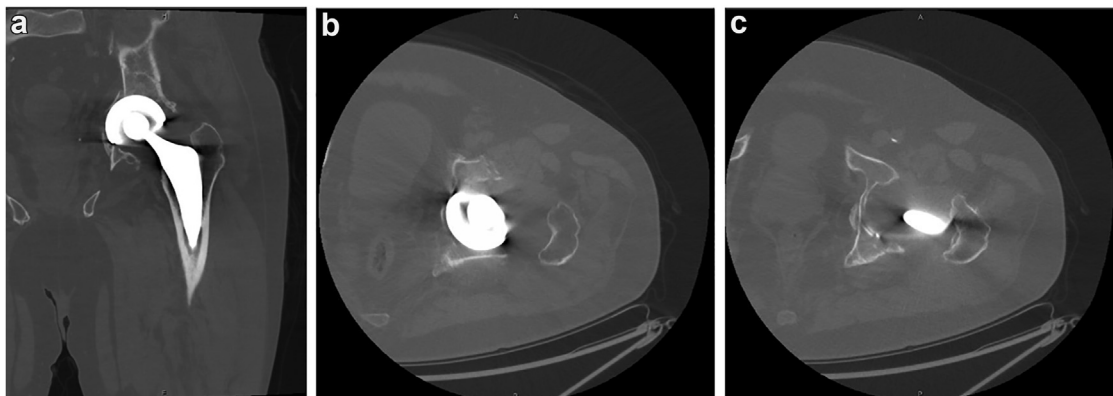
Computed tomography (CT) images with (a) coronal and (b and c) axial cuts demonstrating displaced medial acetabular wall fracture and minimally displaced anterior and posterior wall fractures.
